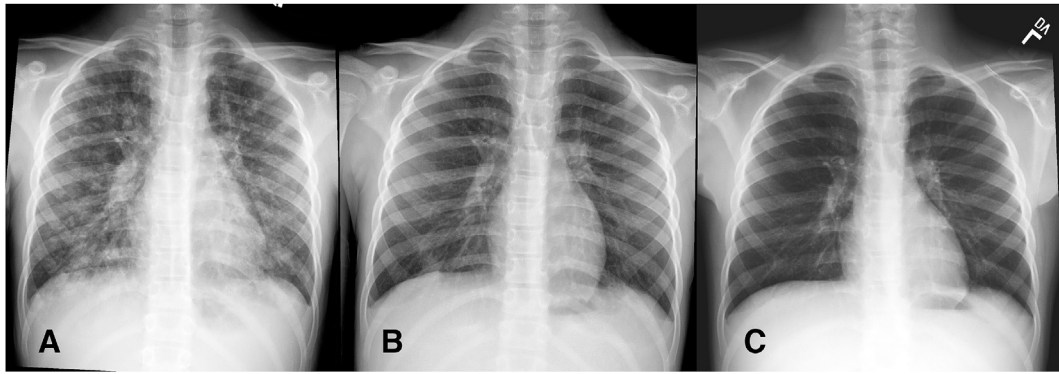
The patient's initial chest radiograph at our facility at time of admission, demonstrating diffuse reticulonodular lung opacities (a). Marked improvement is seen by hospital day 4 (b), and complete radiographic resolution is demonstrated on a repeat outpatient film 21 days after admission (c).
